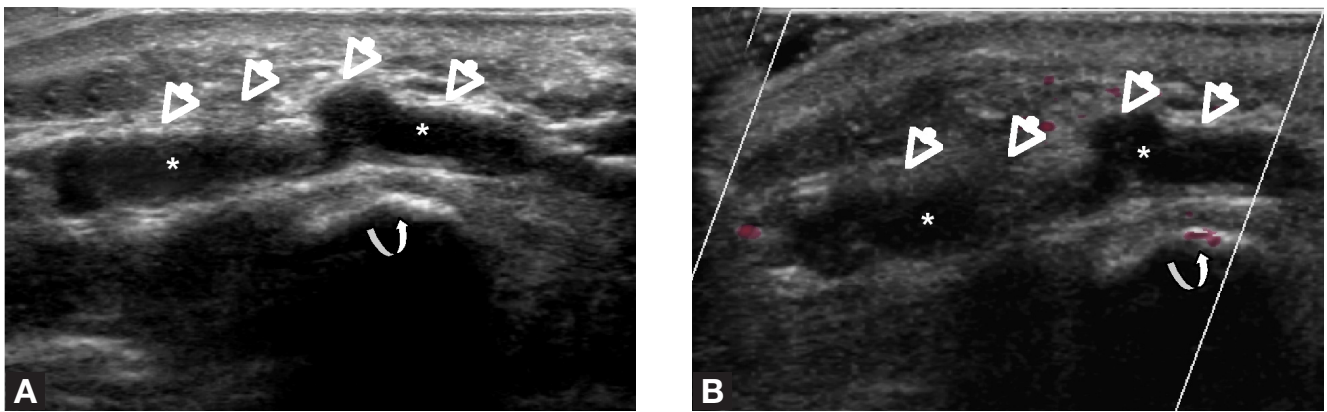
(A) Longitudinal gray scale sonographic image demonstrates echogenic thrombus (asterisks) and aneurysmal “corkscrew” dilatation of the ulnar artery (straight arrows) just distal to the hook of the hamate (curved arrow), reflecting hypothenar hammer syndrome. (B) Longitudinal color Doppler sonographic image shows no flow in the ulnar artery (asterisks) and fusiform “corkscrew” aneurysmal dilatation of the artery (straight arrows) at the hook of the hamate (curved arrow).
